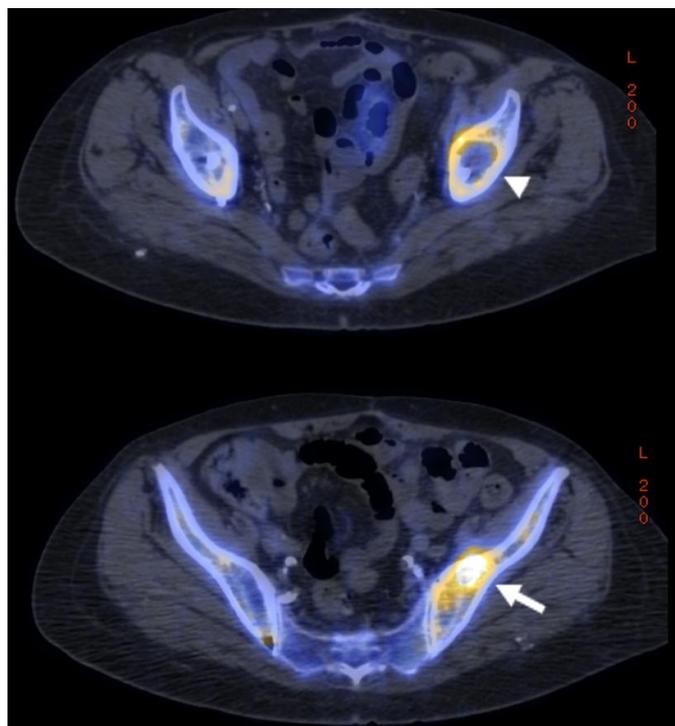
An 80-year-old female with particle disease. These axial images result from fusion of colorized F-18 PET with the axial CT images. (a) PET/CT shows a lucency (arrowhead) superior to the left acetabulum with peripheral uptake of F-18. (b) Moving superiorly, the particle disease extends well above the acetabular joint and is quite intense (arrow). [Helical CT set at 120 kVp and auto mAs on a 16-slice scanner, axial plane, no IV contrast. Acquired for 35 minutes after waiting 1 hour post IV injection of 15.5 mCi F-18 sodium fluoride via a right antecubital vein]
